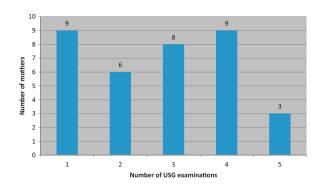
Number of ultrasound examinations during pregnancy.
